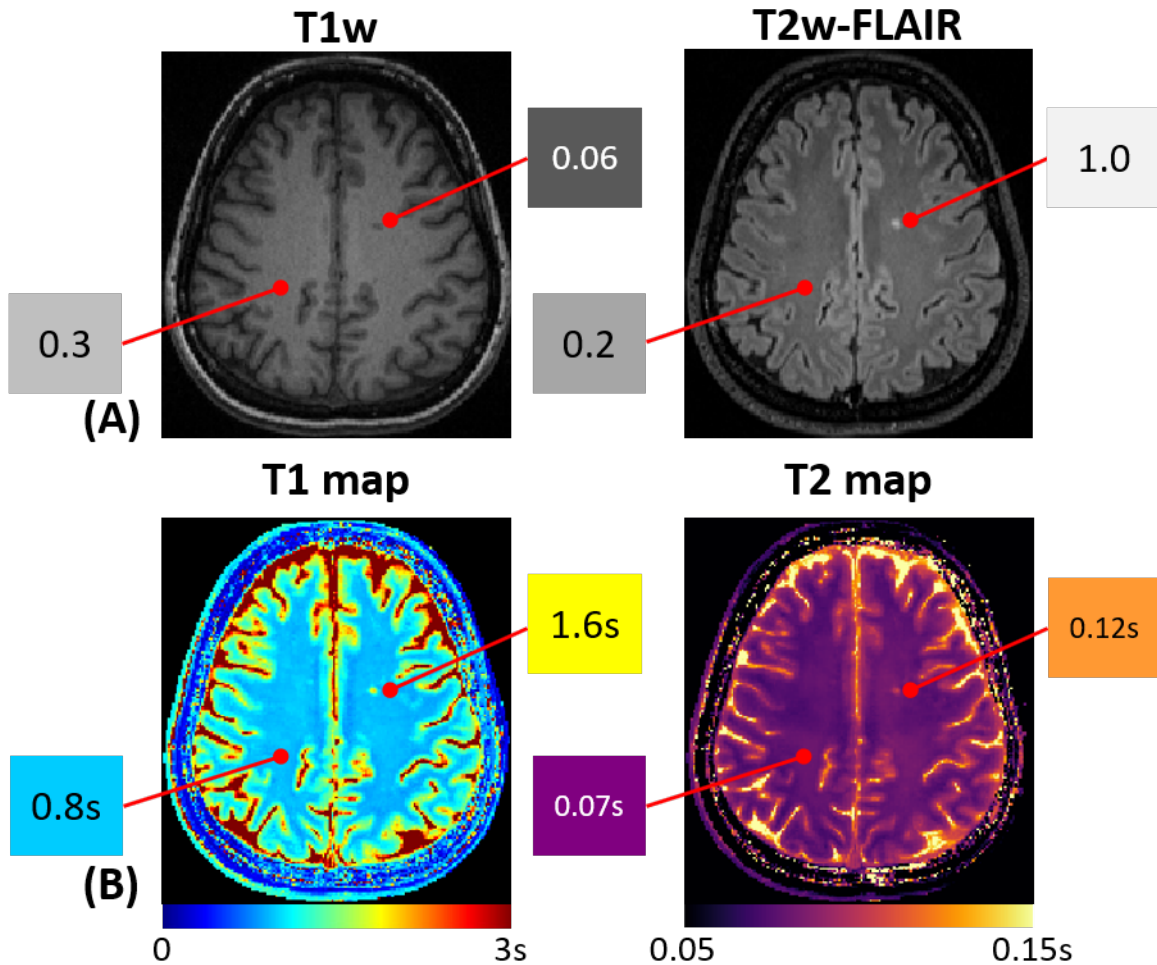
(A) Example clinical qualitative T1w and T2w-FLAIR images with unitless pixel values. (B) Corresponding quantitative T1 and T2 maps whose pixel values are with meaningful physical variables.
